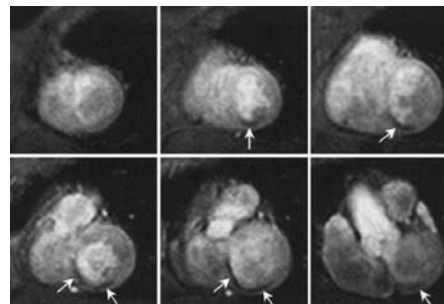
Stress perfusion MR images depict six sections at one time point in a patient with 80% stenosis of the right coronary artery, as determined at conventional angiography. The region of perfusion deficit in the posterior septal wall (arrows) conforms to the vascular territory of the right coronary artery and does not appear in the rest images (not shown), indicating reversible ischemia.
